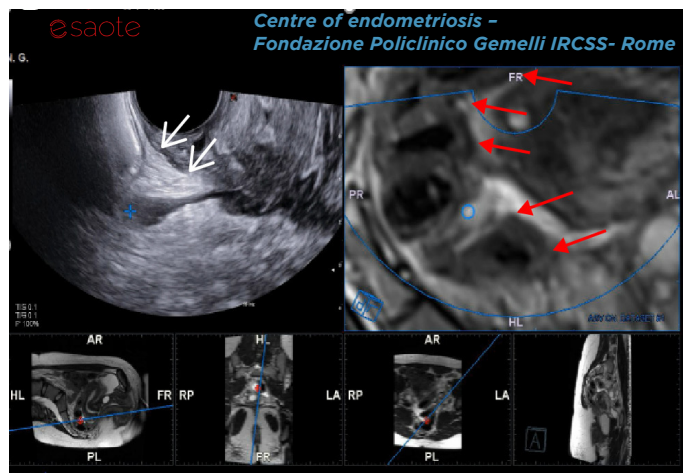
Fusion imaging between US (left) and MRI (right) in the sagittal plane. The white arrows show the retro-cervical area, while the red ones indicate the intestine. + and o represent the endometriotic rectal lesion in US and MRI, respectively.
